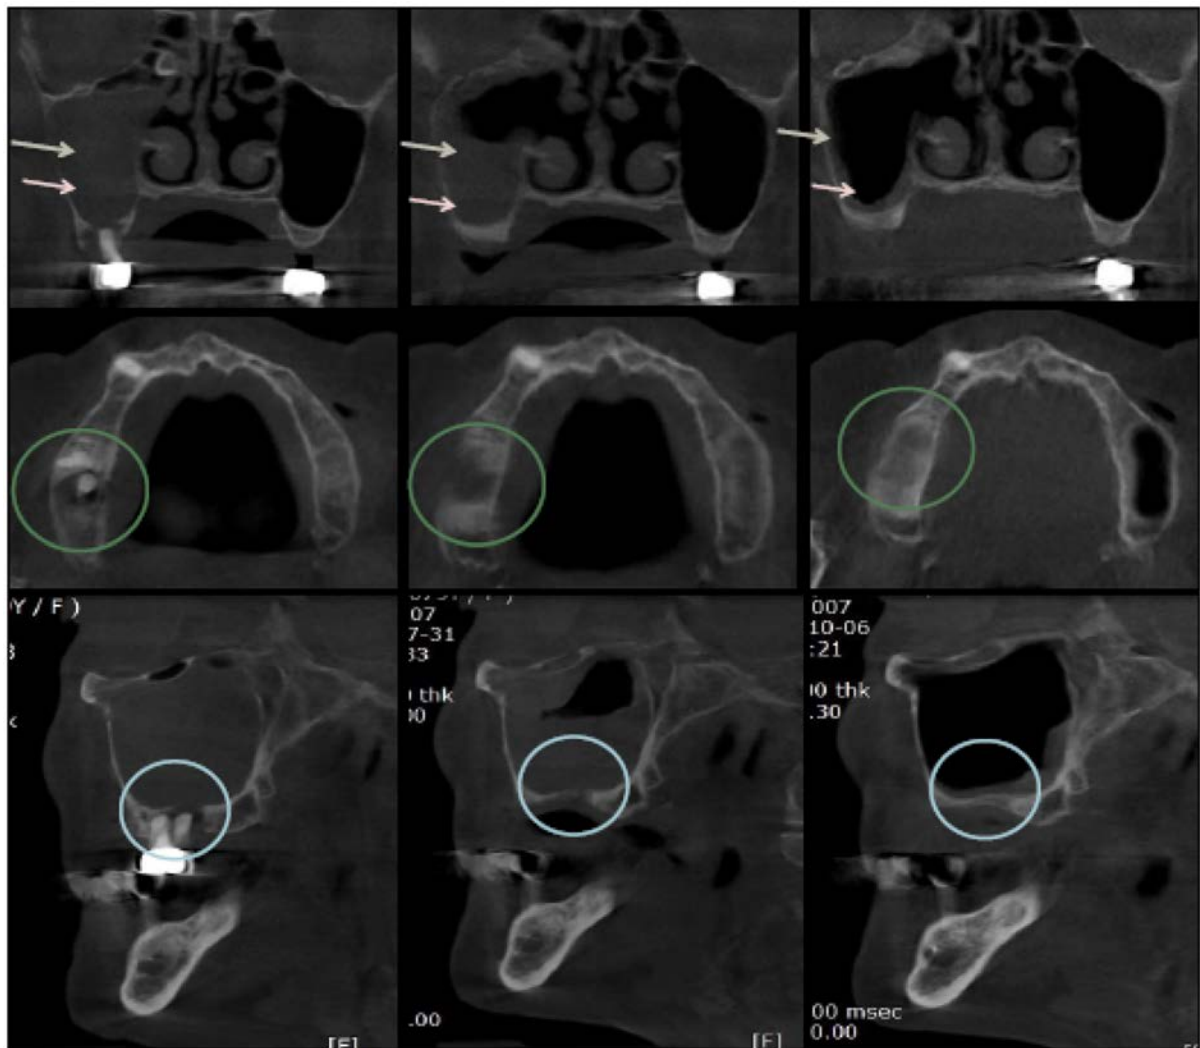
Pre-operative, post-operative 1 week, post-operative 2 months CBCT.
